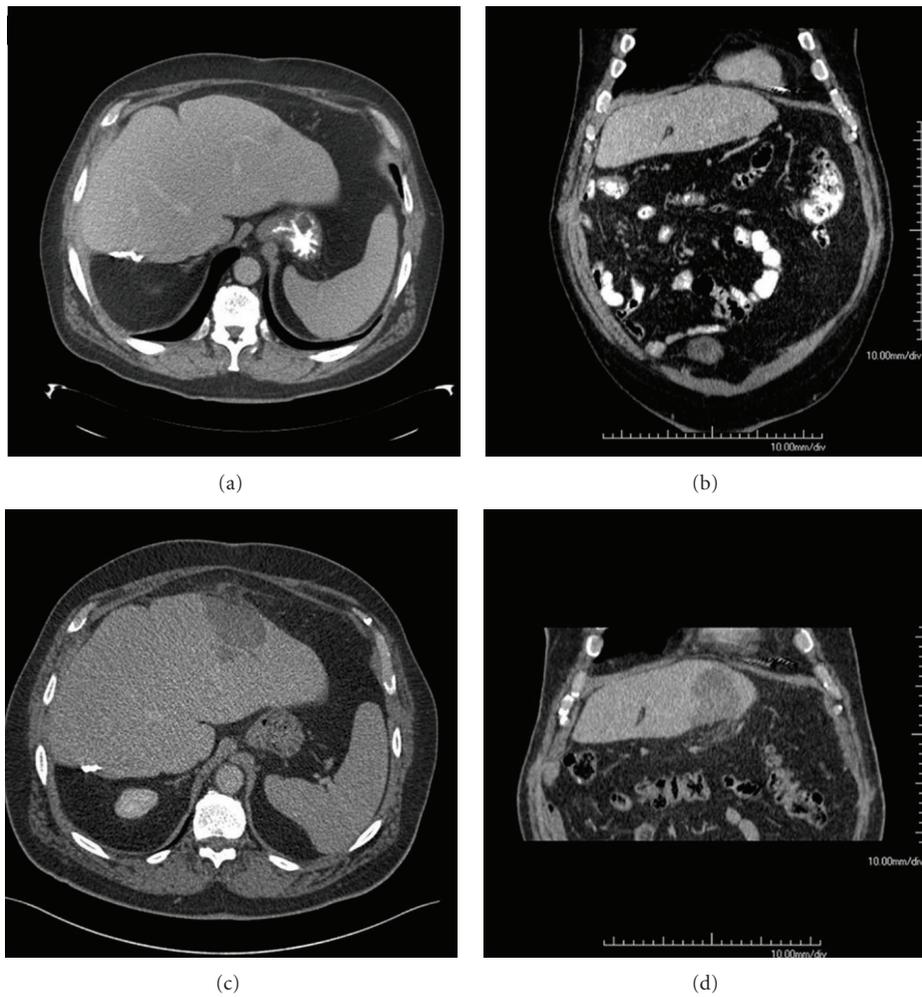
Similarity of Positioning Score-identical (SiPS-id). Example of identical (concordant) pre-RFA CT images and post-RFA CT images, classified as Similarity of Positioning Score-identical (SiPS-id). The pre-RFA CT scan ((a) axial, (b) coronal) and the post-RFA CT scan ((c) axial, (d) coronal) are well comparable.
